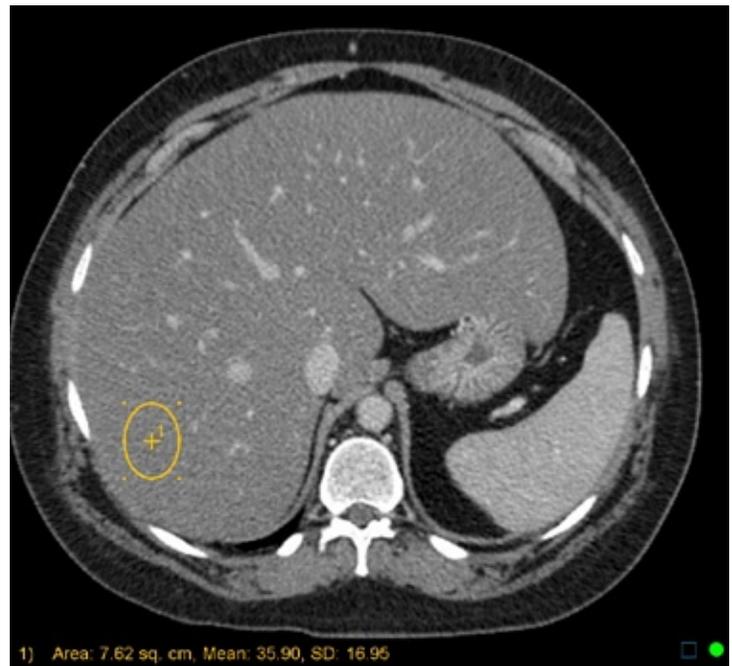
Liver CT with contrast in 33-year-old female demonstrates liver attenuation 36 HU.
